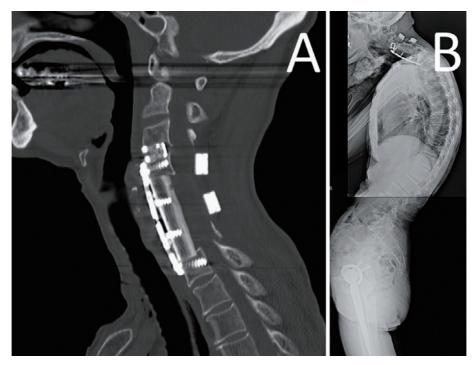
Images after second operation (anterior decompression and fusion from C3 to C7). (A) Sagittal reconstruction CT just after anterior fusion. (B) Standing lateral X-ray at 13 months shows recurrence of cervical kyphosis and dislodgement of the anterior plate.
